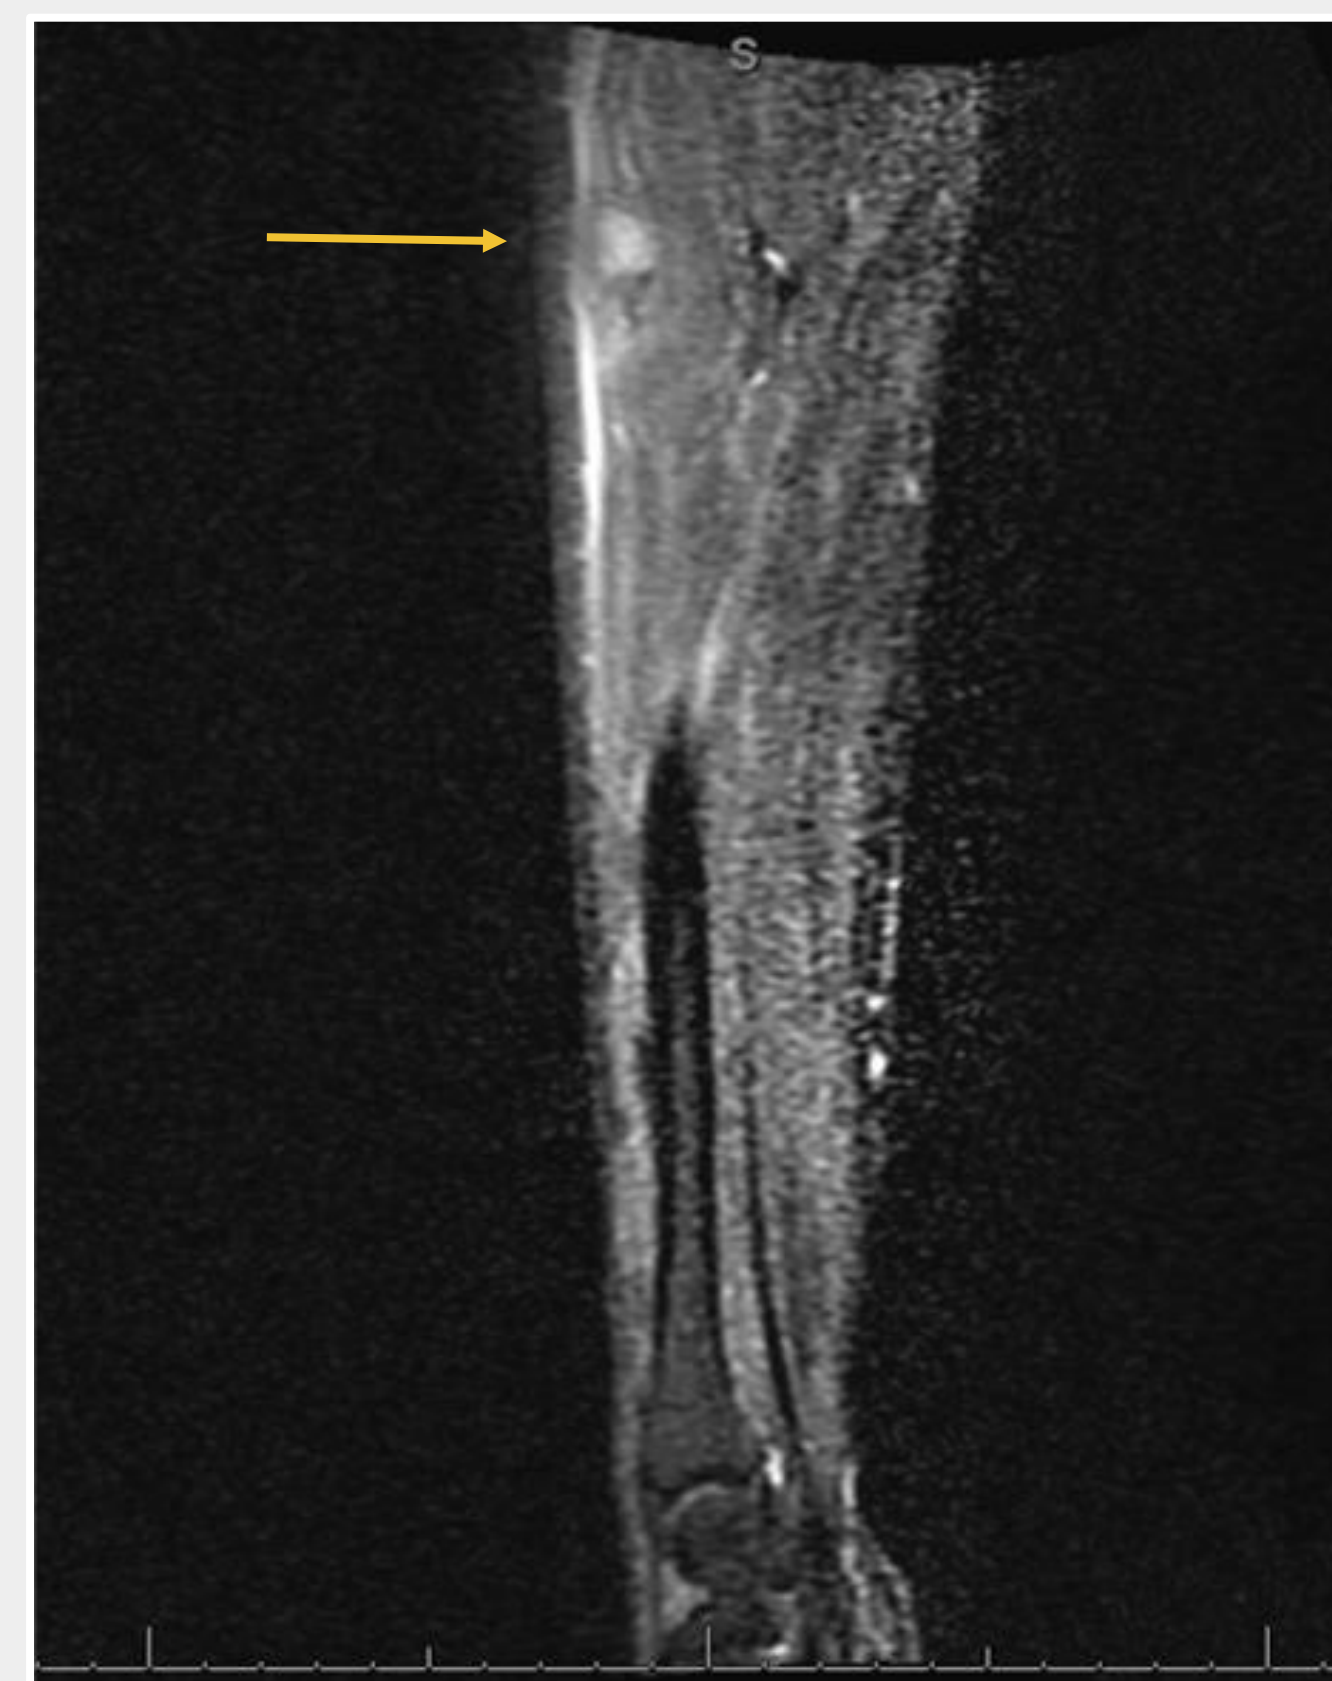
MRI of left arm showing brachioradialis intramuscular hematoma (yellow arrow)
